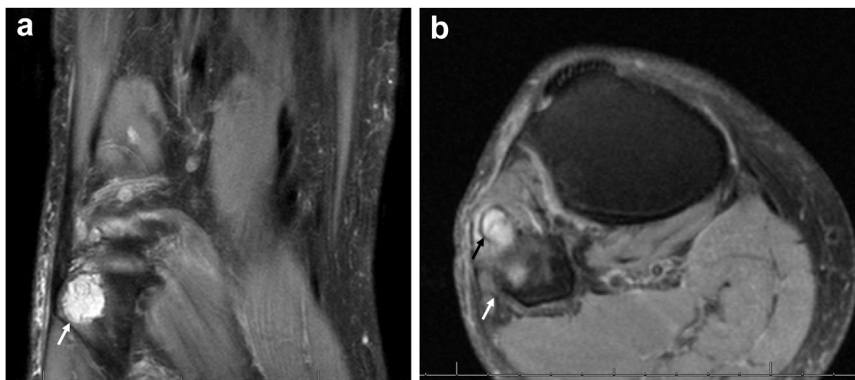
(a) T2 fat-saturated sequence coronal MRI demonstrating large cyst about the lateral side of the knee about the proximal tibio-fibular joint (white arrow). (b) T2 fat-saturated sequence axial MRI showing the large cyst and identifying the common peroneal nerve wrapping around the fibular head (white arrow) and being compressed by the cyst (black arrow) at that site. MRI, magnetic resonance imaging.
